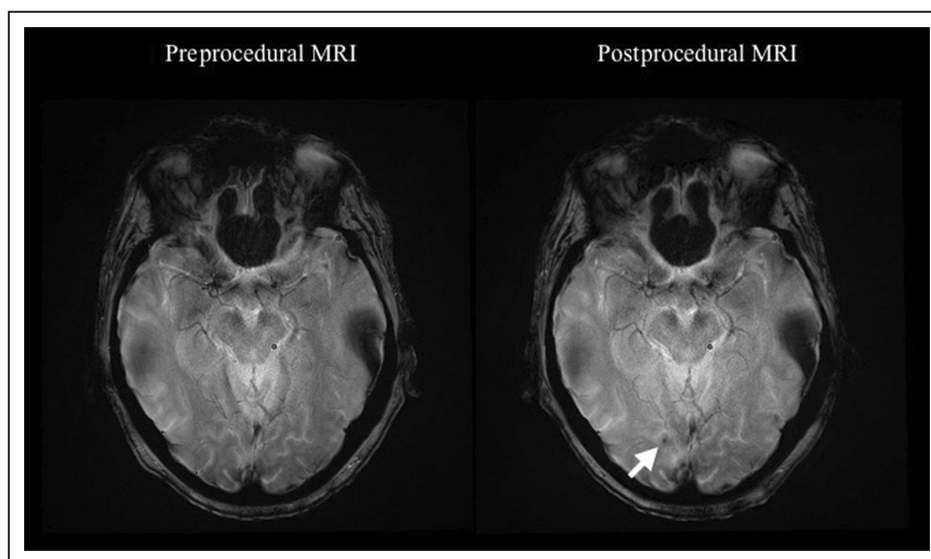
New cerebral microbleed after catheter-based structural heart intervention. MRI indicates magnetic resonance imaging.
